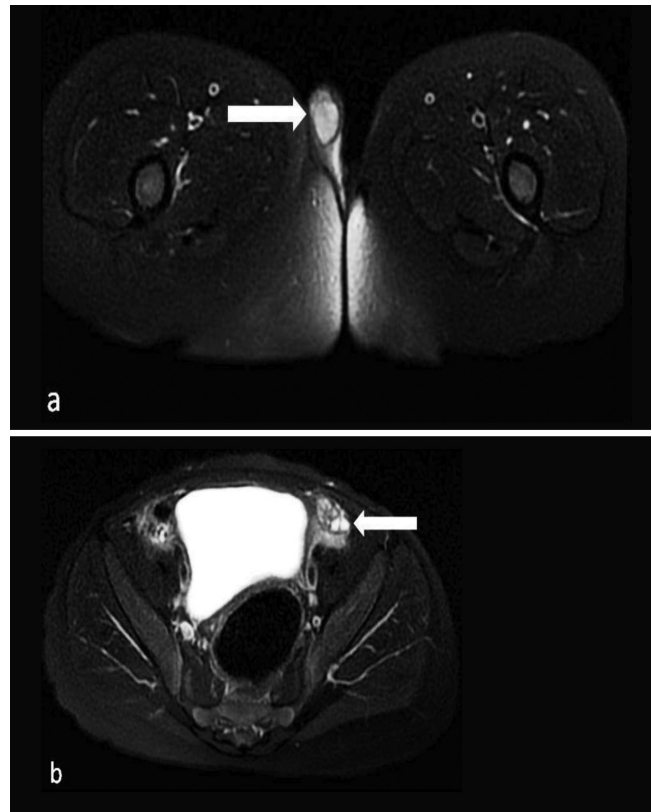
Axial fat-suppressed T2-weighted image of the magnetic resonance sequence shows testicular tissue in the right scrotum. Normal epididymis and spermatic cord are observed in association with this testicular structure (a). Ovarian tissue with millimetric follicular cysts is present in the left inguinal region (b)
